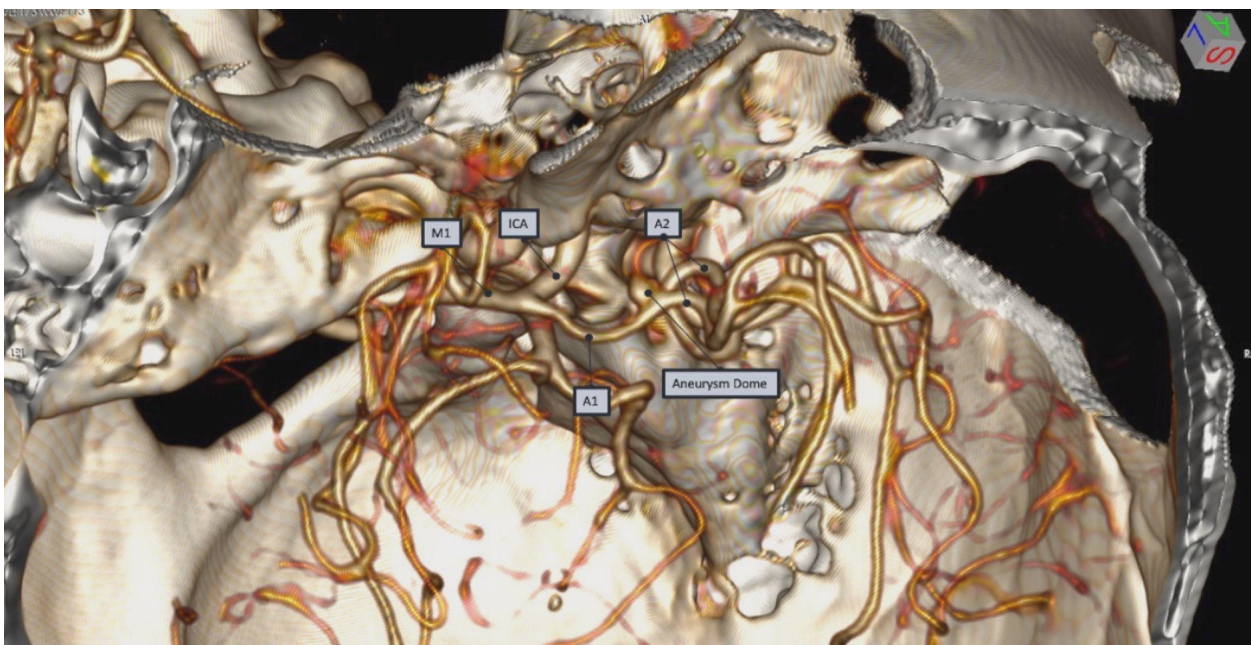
Pre-operative imaging of Computed tomography angiography (CTA) shows saccular aneurysm on right AComm artery.
